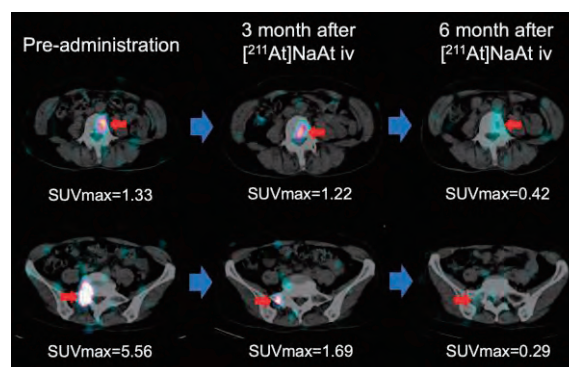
^{131}I -SPECT image after administration of astatine (^{211}At): The lesions have almost completely disappeared (arrow).
